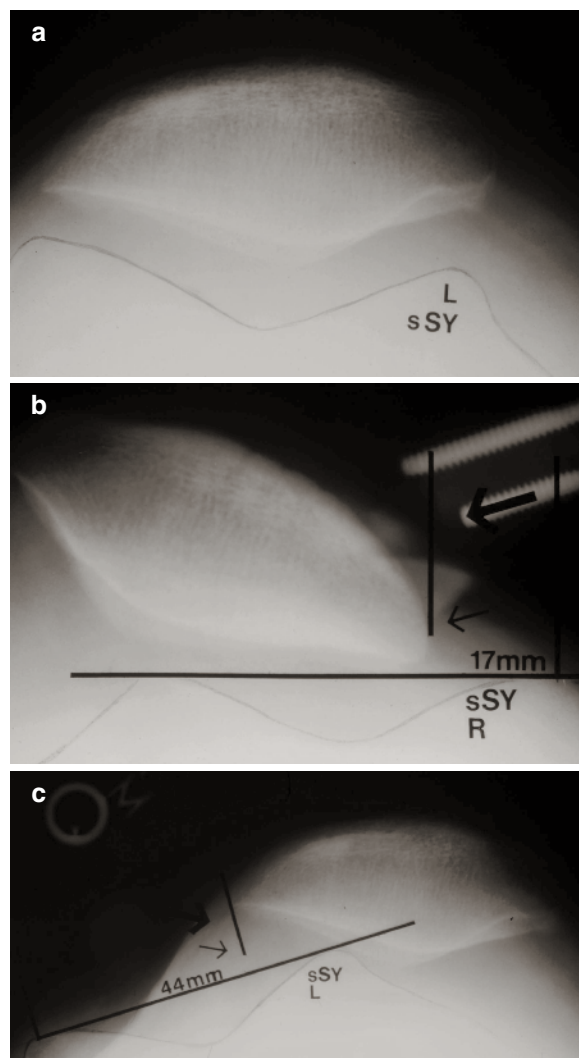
(a) Axial view of PF joint in a patient who had undergone nine surgeries for patellar instability. (b) Medial stress radiograph of the asymptomatic PF joint, showing an excursion of 17 mm with the median ridge of the patella just ready to cross the anterior surface of the medial trochlear condyle. (c) Medial stress radiograph of the symptomatic knee demonstrates 44 mm of excursion with a medial dislocation of the patella. The increase from the asymptomatic (normal) side is 27 mm
